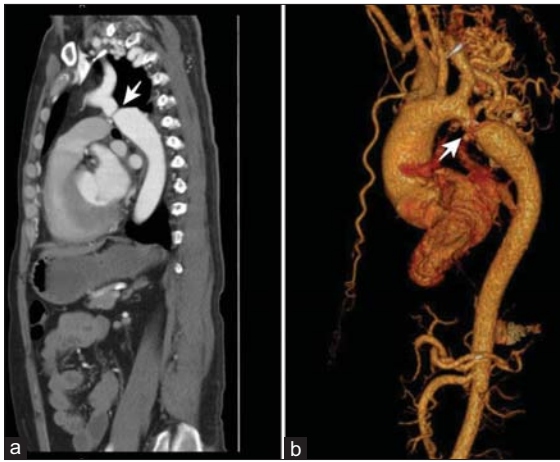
(a) Sagittal computed tomography angiography at the emergency department showing juxtaductal coarctation of aorta. (b) Computed tomography angiography (three-dimensional reconstruction image) demonstrating coarctation of aorta and abundant collateral vessels
